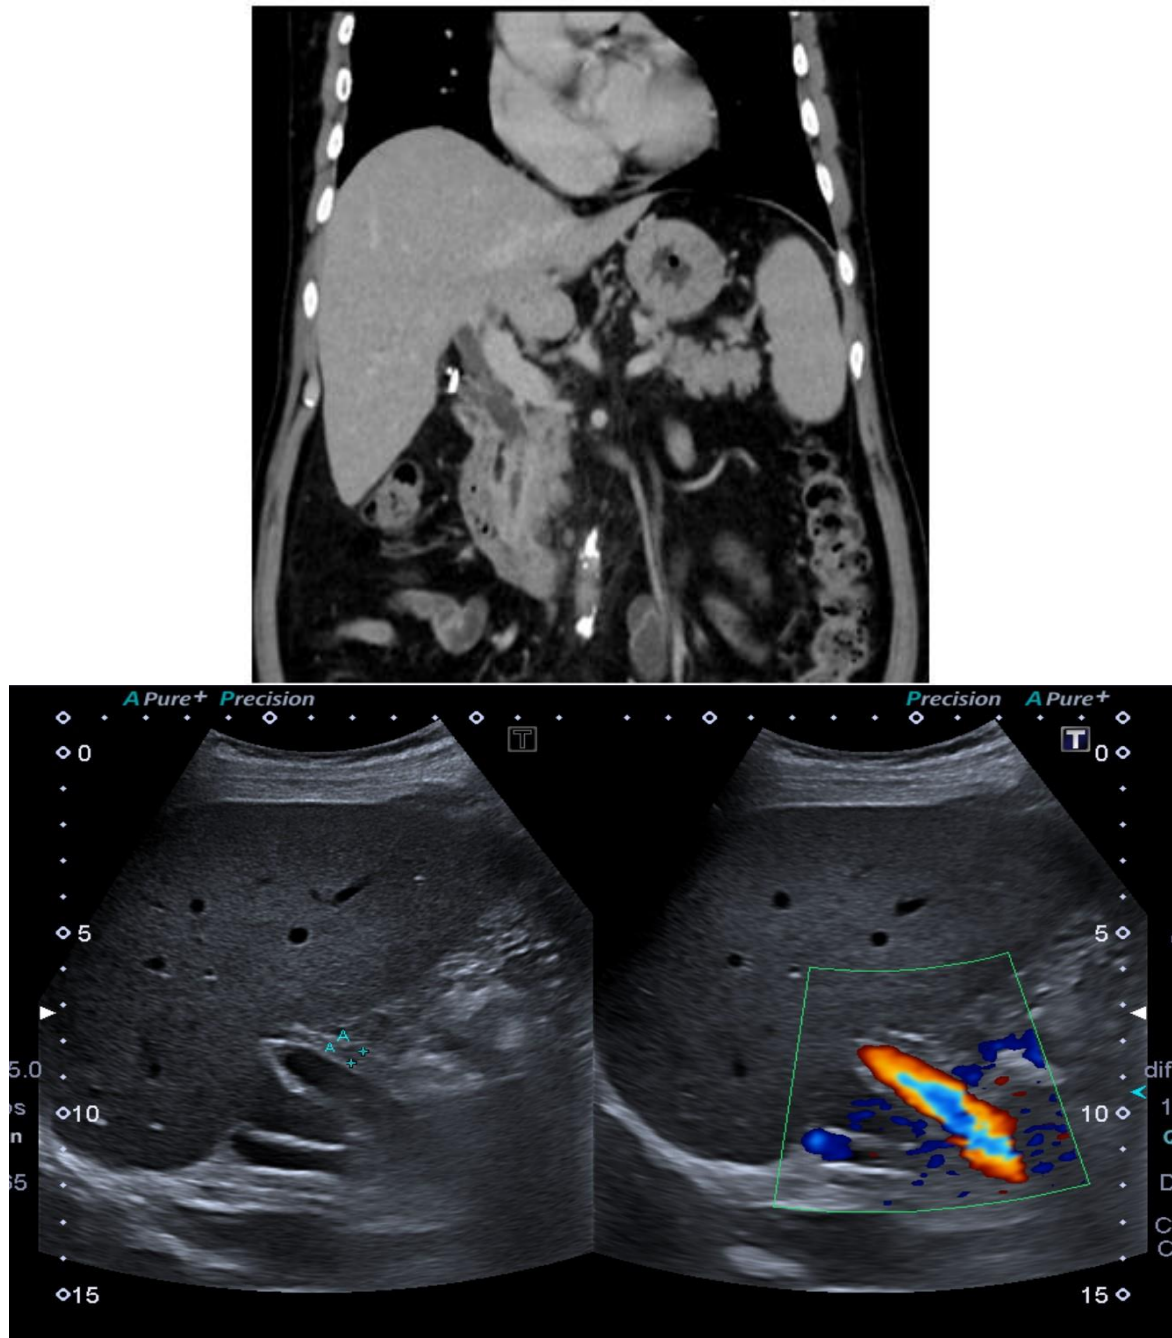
Post treatment patients ultrasound abdomen was performed which was normal. Normal CBD & intrahepatic ducts
